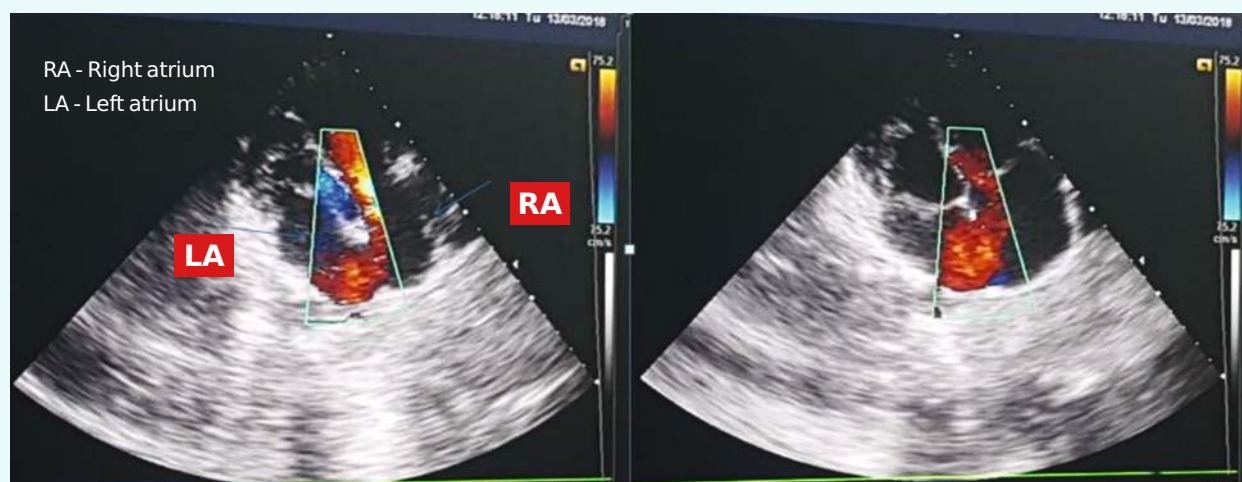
Echocardiography - ostium secundum type atrial septal defect with left to right shunt
